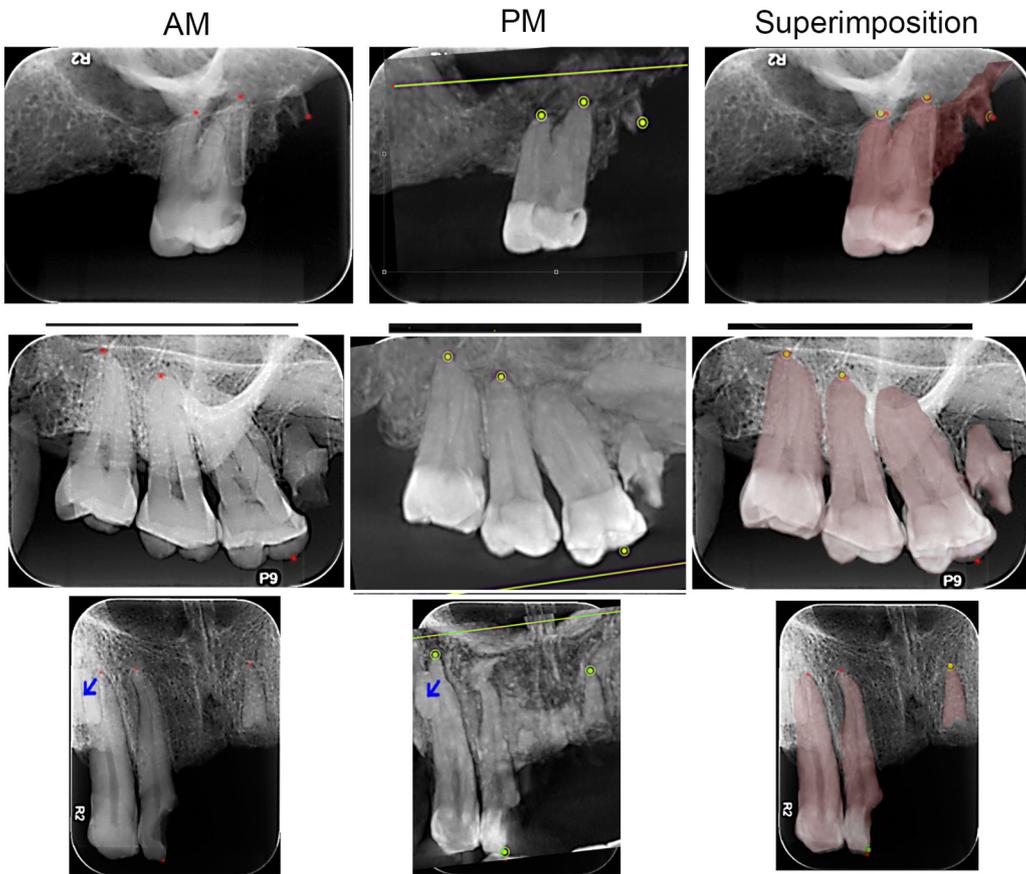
Radiograph (AM), image from CBCT (PM) and superimpositions of 3 cases.
